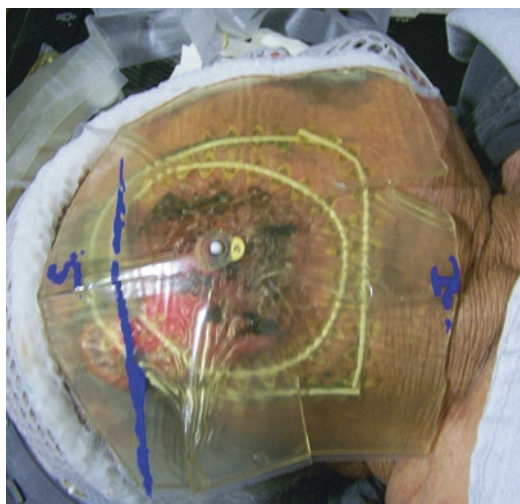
Setup for electron beam treatment of a 93-year-old man with a locally advanced squamous cell carcinoma of the right preauricular region. The head and neck are immobilized with a custom-made mask. The lesion and the desired treatment field are outlined with radiopaque wire, which allows for visualization of the area on the planning CT scan. The external auditory canal is filled with Domeboro drops and TX-151, a pink tissue-equivalent putty, to alleviate dose inhomogeneities caused by the irregular surface of the ear. The entire field plus a wide margin is covered with 3-mm bolus to produce a homogenous dose distribution throughout the treated field. Not shown here, an additional piece of bolus 2-cm thick was applied to the superior aspect of the treatment field to further pull the dose away from the underlying temporal lobe
